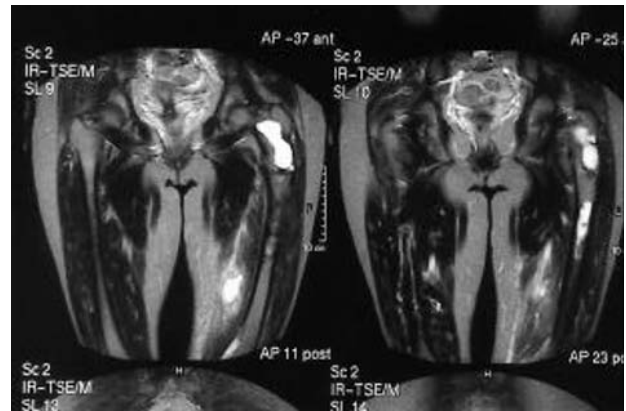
Postoperative MRI showed cystic hemorrhagic areas at the medial part of the left thigh and three osseous lesions at the femoral neck-proximal metaphyseal, mid diaphyseal and distal diaphyseal regions.
